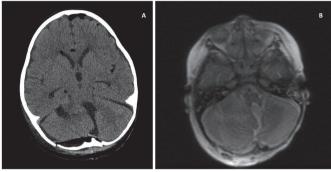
A. CT after surgery. B. NMR without contrast after surgery
